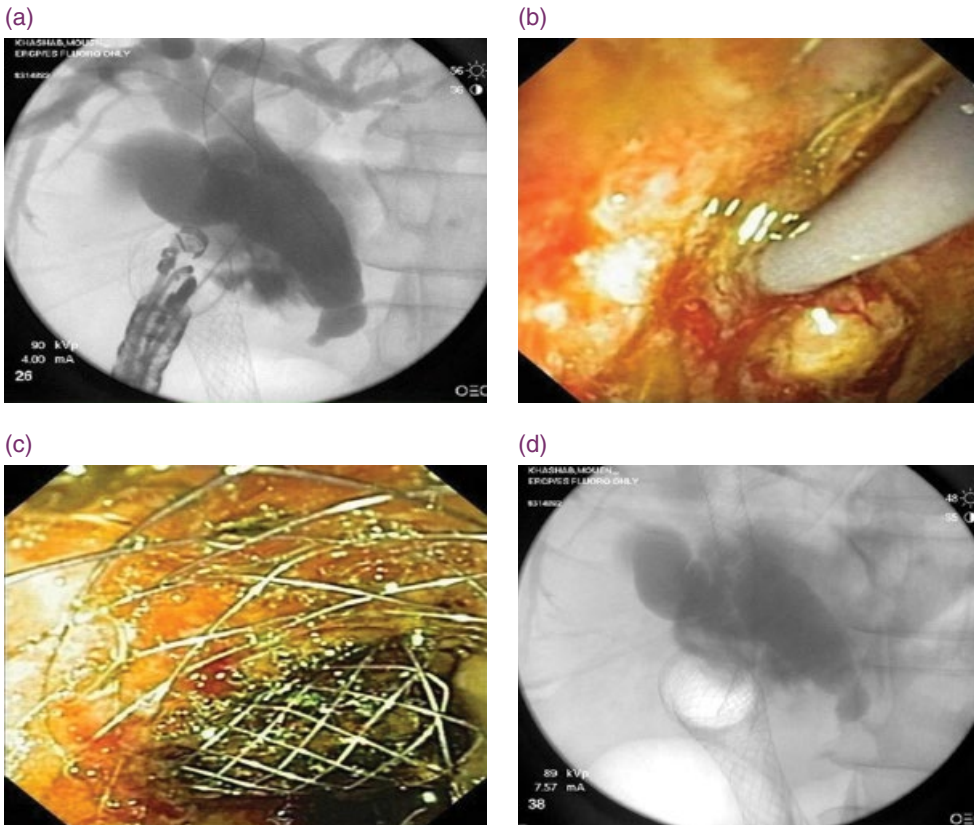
Endoscopic ultrasound guided biliary drainage using a direct transluminal technique in a patient with a pre-existing duodenal stent. (a) The bile duct was punctured with a 19 gauge needle and dye was injected. Antegrade cholangiography revealed a dilated bile duct with a tight distal stricture. A 0.035 inch hydrophilic wire was advanced to the proximal biliary system. (b) Choledochoduodenostomy using a 7 Fr Soehendra dilator. (c) A fully covered biliary self-expandable metal stent (SEMS) was placed with its distal end in the duodenal bulb exiting through the enteral stent mesh. (d) Fluoroscopy confirmed the position of the biliary SEMS and enteral stent.
